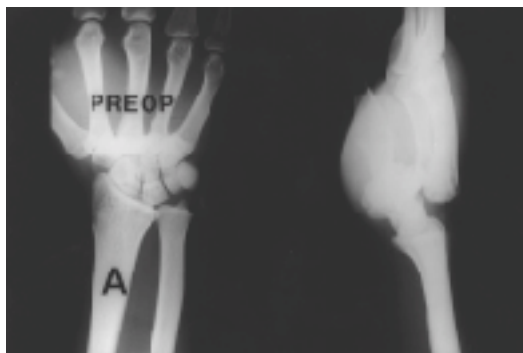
Initial radiographs of the right wrist showing dorsal dislocation of carpometacarpal joints excluding thumb
